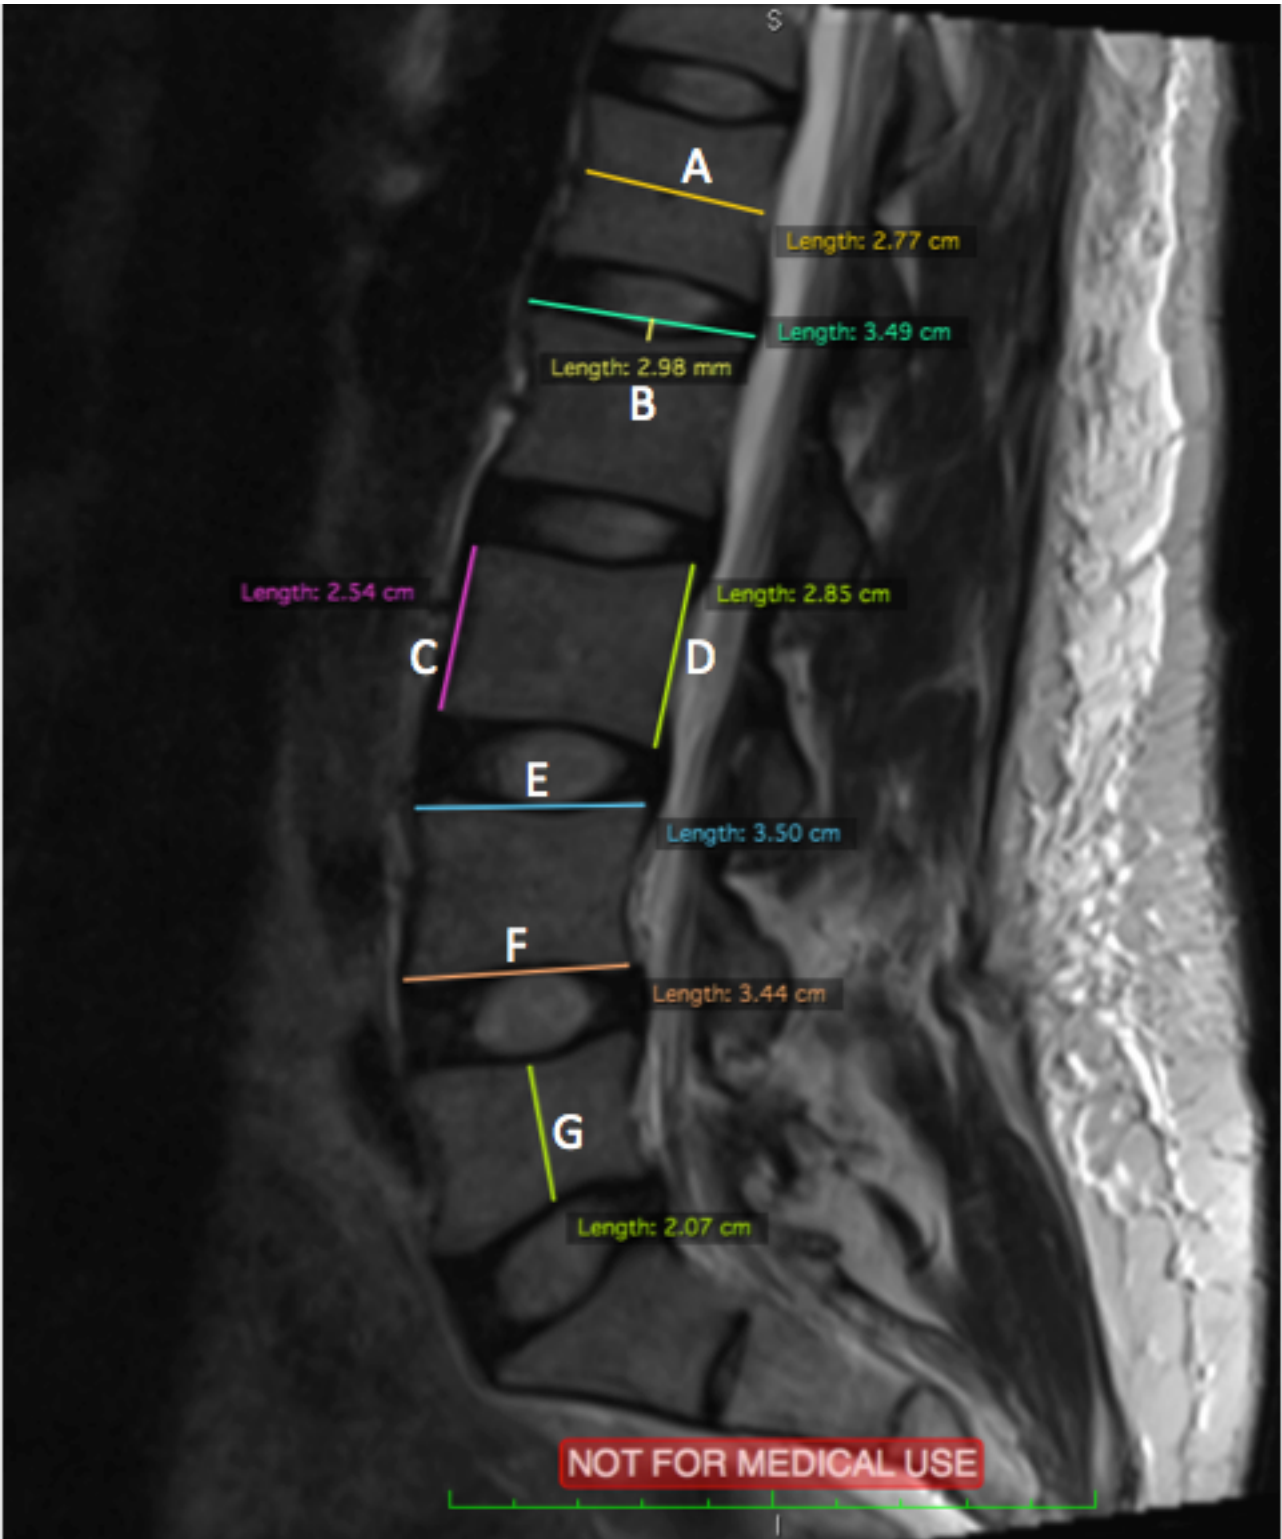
Sagittal MRI scan with measurements of A (Sagittal Vertebrae Body Width), B (Concavity Height), C (Anterior Vertebral Height), D (Posterior Vertebral Height), E (Superior Vertebral Body Length), F (Inferior Vertebral Body Height), and G (Sagittal Vertebral Body Height)
